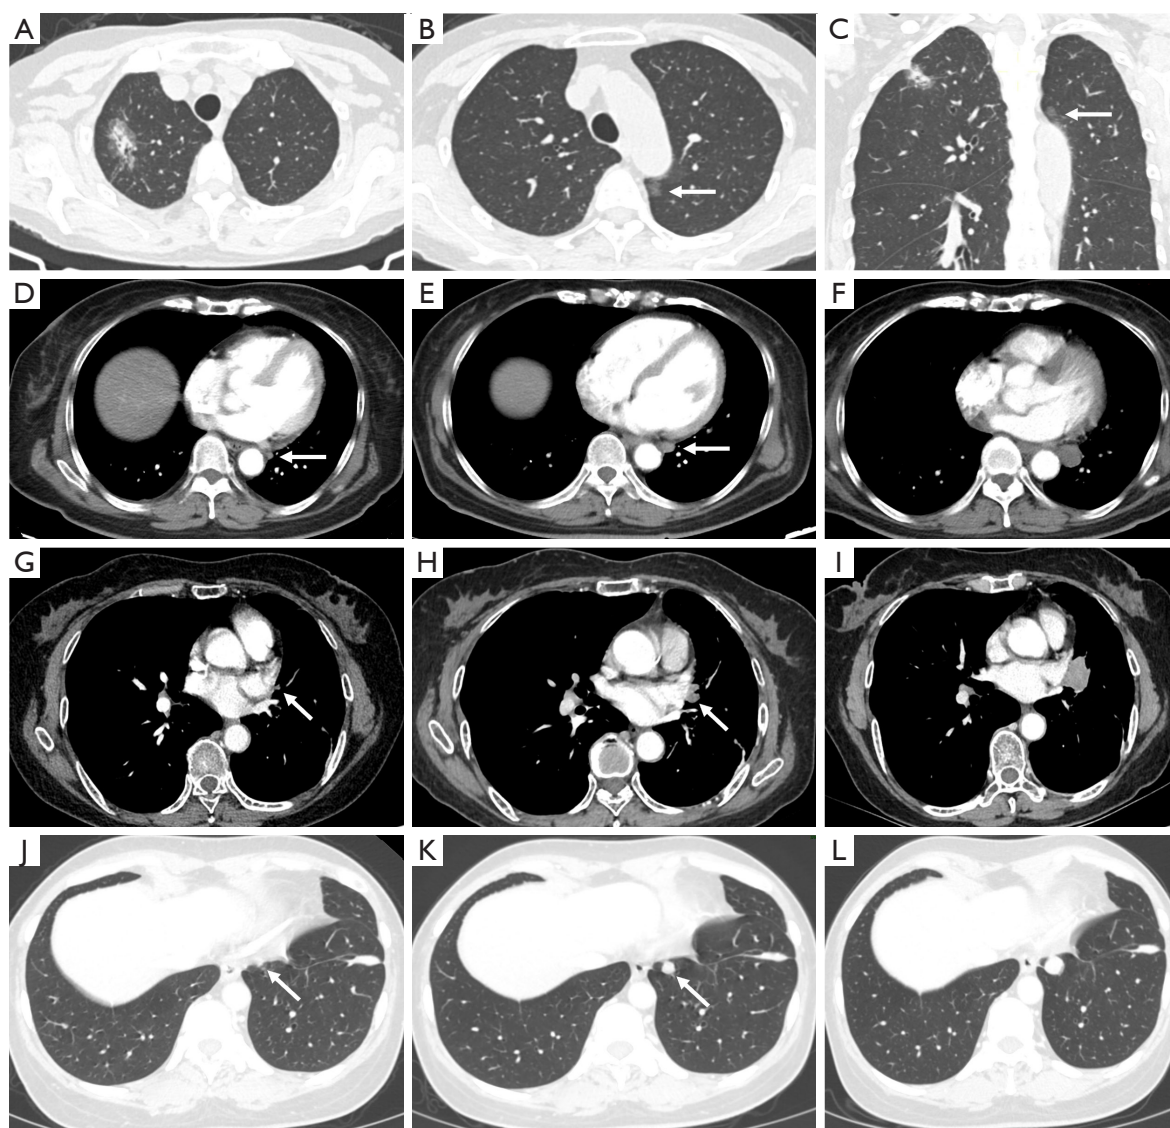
Blind spots of lung: the para-aortic, paramediastinal, pericardiac and para-diaphragm areas. (A-C) A 66-year-old female with adenocarcinoma of the right upper lung lobe. The radiologist overlooked the ground-glass opacity near the aortic arch in the left upper lobe (arrows) (B,C) because of the more noticeable lesion in the right upper lobe. (D-F) A 69-year-old female with a missed solid nodule in the first two CT images near the poster mediastinum in the left lower lobe (arrows) that gradually grew in size during follow-up. (G-I) A 63-year-old female after resection of the left lung adenocarcinoma. A new small nodule near the left pericardium (arrows) was missed in the first two CT exam, showing gradual enlargement during the follow-up period, and subsequent confirmed adenocarcinoma by biopsy. (J-L) A 52-year-old female after resection of the right upper lung lobe adenocarcinoma. (J,K) A new nodule near the diaphragm had been growing in size (arrows), raising concerns about it being a metastasis. Due to its hidden location and interference from a nearby shadow, there is a risk of overlooking this lesion. CT, computed tomography.
